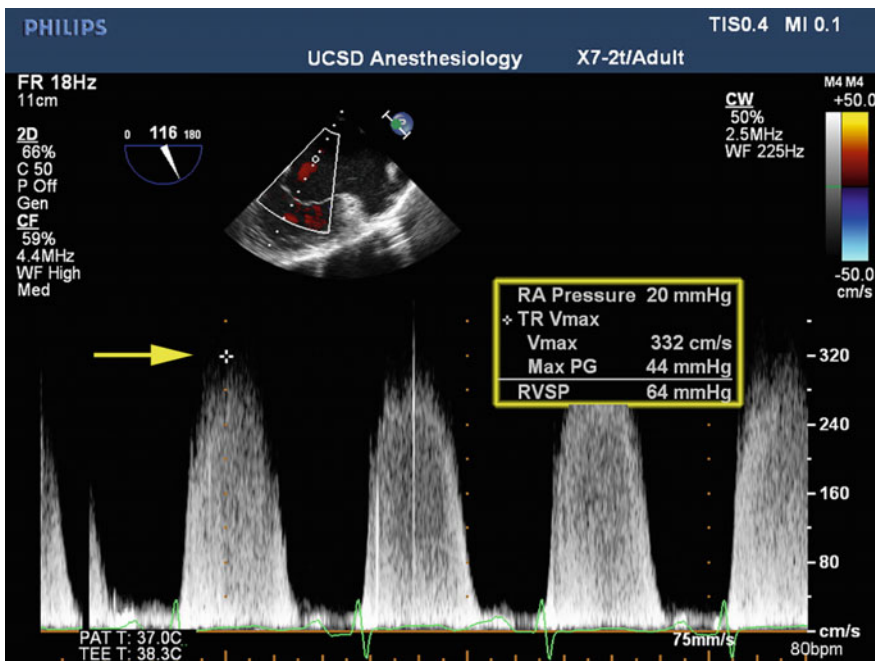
A continuous wave Doppler profile of a tricuspid regurgitation (TR) jet. The right ventricular systolic pressure (RVSP), which is an estimation of pulmonary artery systolic pressure, is determined by applying the modified Bernoulli equation to the peak regurgitant velocity in addition to the CVP (RA Pressure). RA right atrial; Vmax maximum velocity; PG pressure gradient
